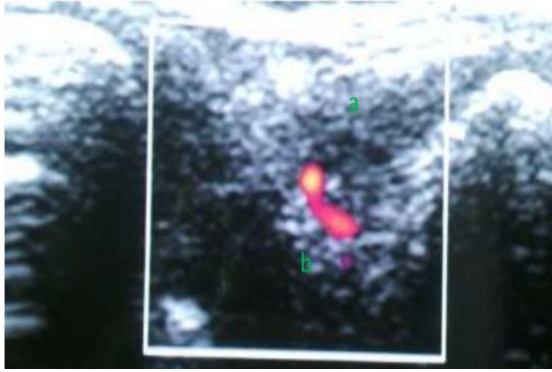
showing a transverse scan of the dorsal aspect of right wrist joint of RA patient with synovial hypertrophy (a), and mild vascularity is seen as power Doppler signal of grade 1 (b).
